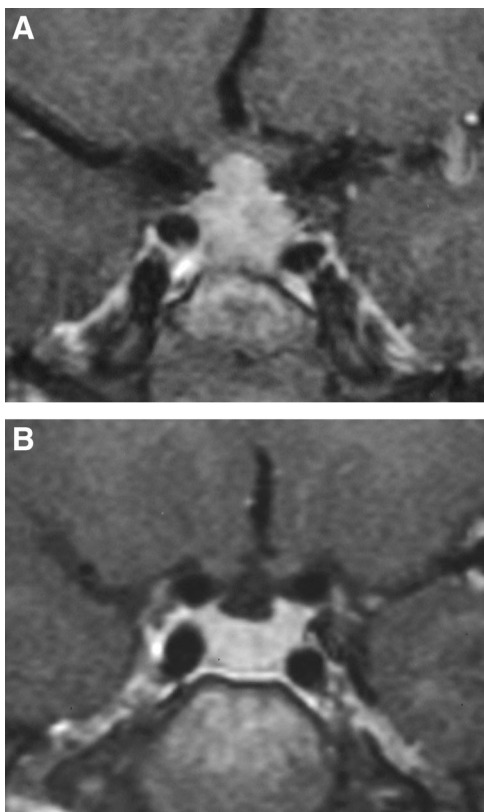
A, Contrast-enhanced T1-weighted coronal magnetic resonance image of a pituitary gland showing a symmetrically enlarged gland with elevation of the optic chiasm. B, Contrast-enhanced T1-weighted coronal magnetic resonance image of the pituitary gland showing shrinkage of the hyperplastic gland after treatment of primary hypothyroidism.
